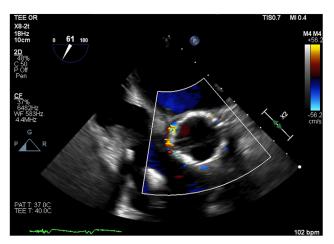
Postoperative two-dimensional TEE, midesophageal aortic valve short-axis view with color-flow Doppler, demonstrates marked PVR around the TAVI device.
